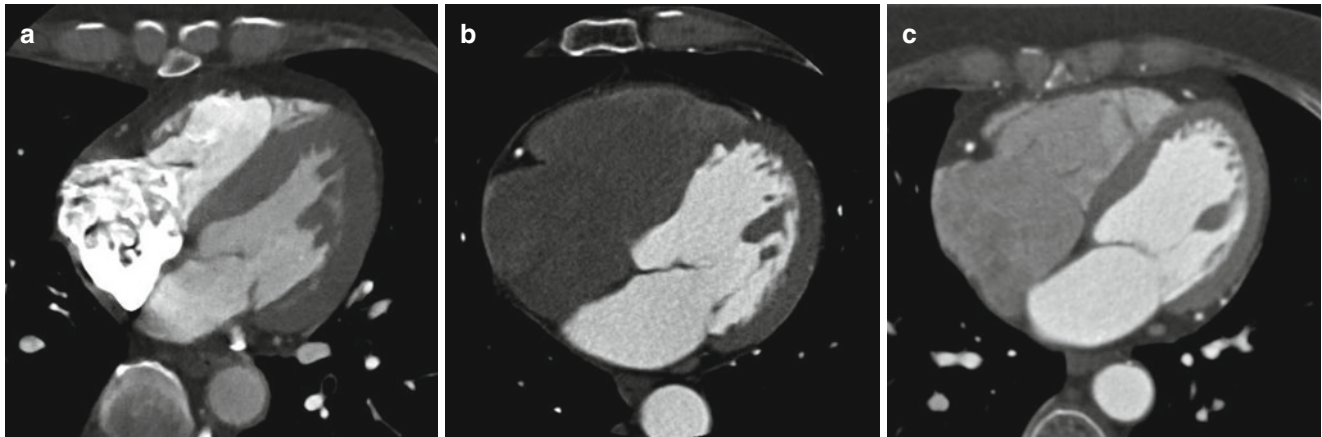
Contrast injection protocols. (a) In uniphasic protocol, transaxial CT image shows a streak beam hardening artifact caused by non-diluted dense contrast media in the right atrium. (b) In biphasic protocol, shows excellent enhancement of left heart but weakness in the evaluation
